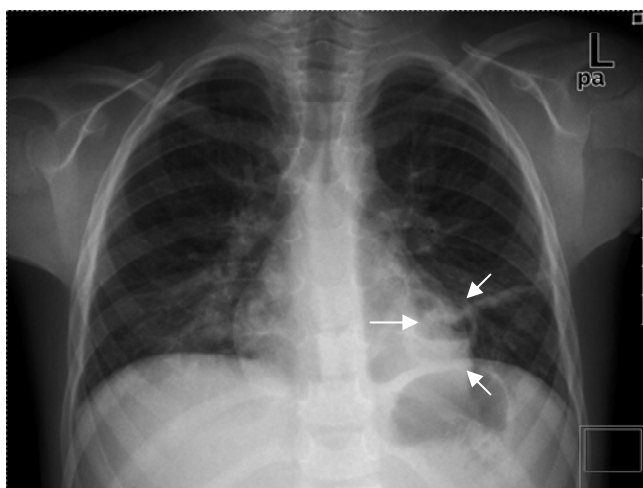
Chest X-Ray of the patient. Air-fluid level in the left lung considers lung abscess (Lung abscess is marked with arrows)
